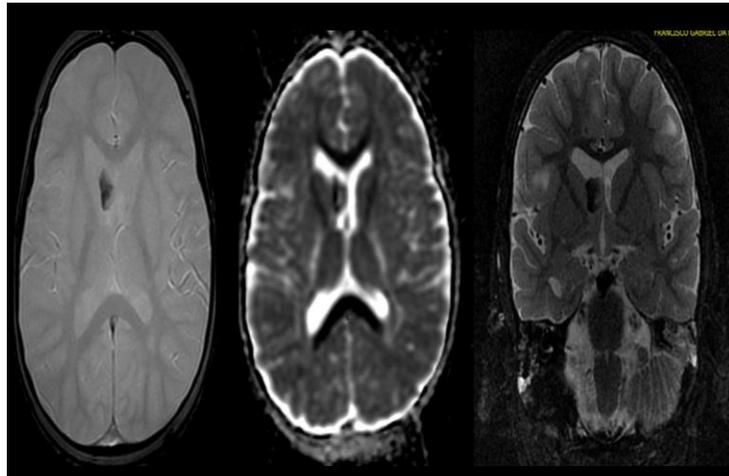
RM axial sections A, T2 FLAIR; B, post-contrast T1; C, T2 GRE; D, DWI; And, coronal STIR section demonstrates an expansive lesion (arrows) located in the anterior horn of the right lateral ventricle, with enhancement after injection of contrast medium, with central calcification, suggestive of subependymal giant cell astrocytoma, in a 2-year-old patient, gender masculine.
